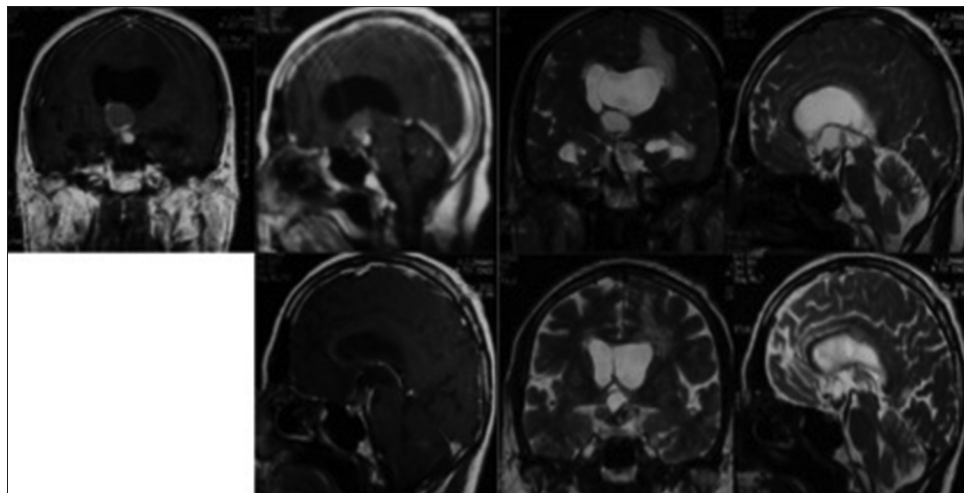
The patient underwent cystocisternostomy. Top row images 1 and 2 – Magnetic resonance imaging T1 contrast coronal and sagittal section shows contrast-enhancing cystic craniopharyngioma reaching up to foramen of Monro with ventriculomegaly. Top row images 3 and 4 – Magnetic resonance imaging T2 coronal and sagittal section shows hyperintense cystic craniopharyngioma Bottom row images 1-3 – Magnetic resonance imaging T1 contrast sagittal, T2 coronal and sagittal sections show reduction and regression of cystic cavity and improvement of ventriculomegaly
